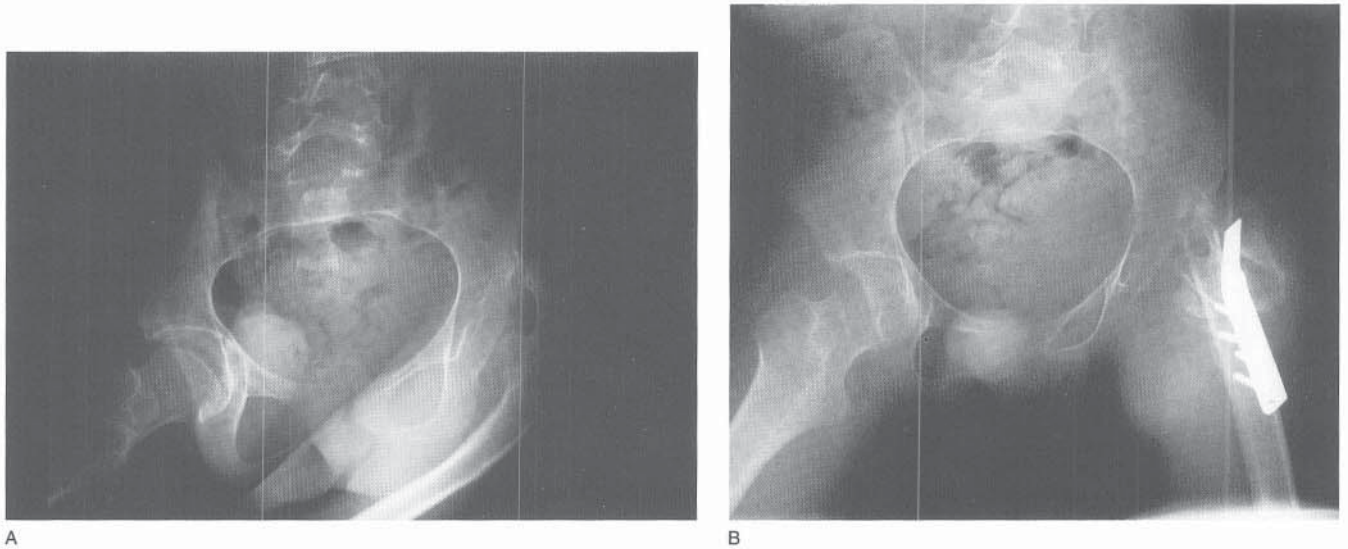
A, Pelvic radiograph of a 16-year-old boy with a painful, stiff, dislocated left hip. B, A valgus osteotomy improved seating and hygiene.
